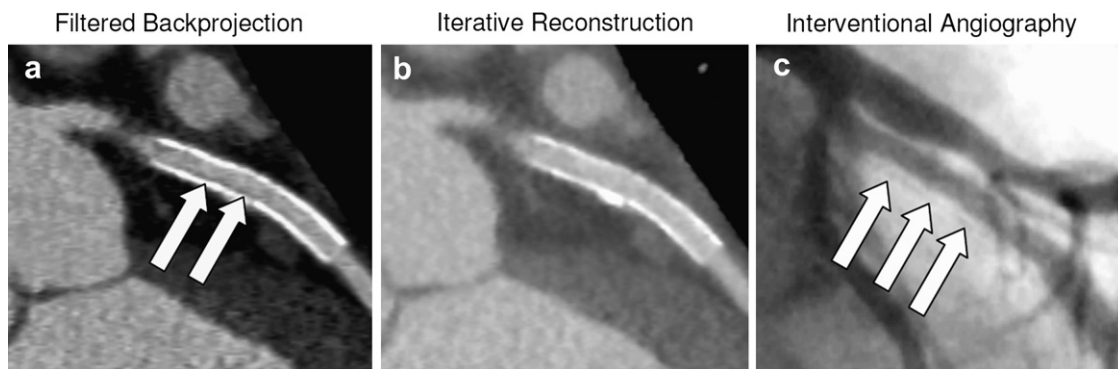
Can differences in image content be excluded between standard and iterative reconstruction? In the case of a coronary artery CT angiography, the standard FBP reconstruction revealed a hypodense seam along the stent indicating proliferation of the vessel intima which may ultimately lead to stent stenosis (a), This seam is not visible in IR (b), but was confirmed by interventional angiography (c). (Courtesy of Dr. S. Achenbach, University of Giessen).
